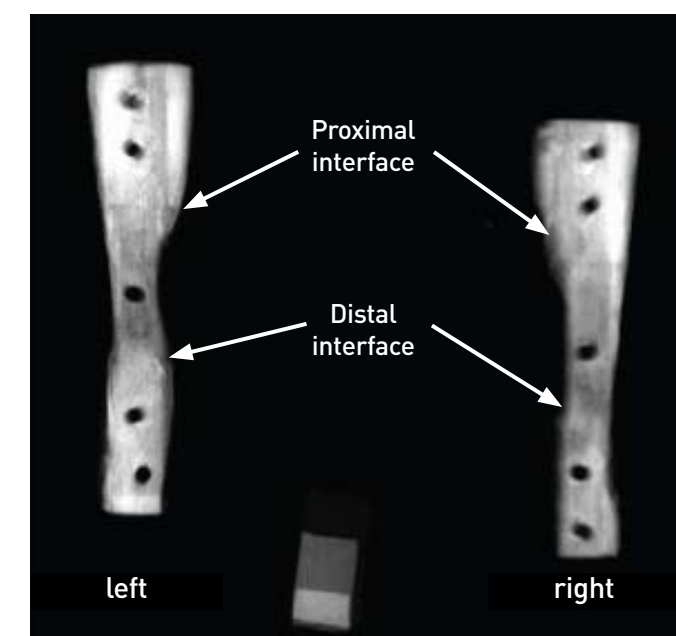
High resolution anteroposterior radiographs show grafts processed with the standard cleaning process (left) and the ATP process (right).
